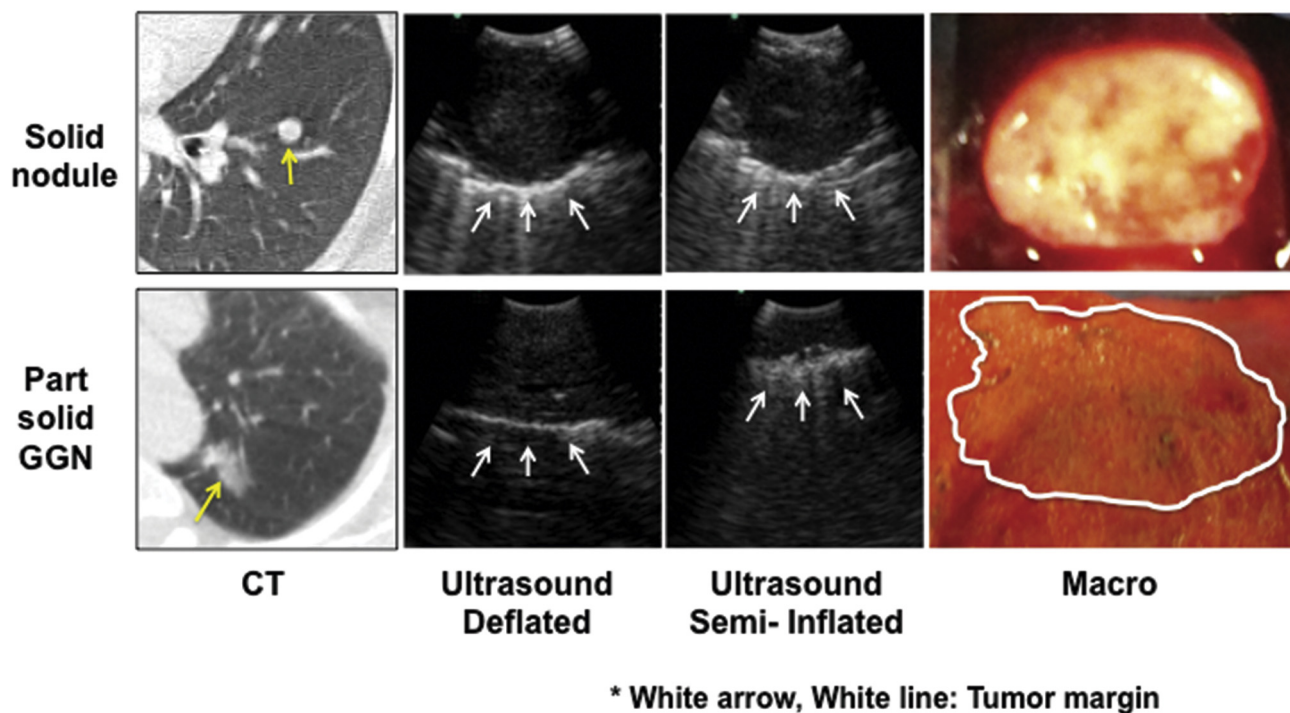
Comparison of computed tomography (CT), ultrasonography, and macroscopic (Macro) images between solid nodule and part solid ground-glass nodules (GGN) in both deflated and semiinflated states. Tumor margins are easier to visualize in the deflated state (left) compared with when the lung is semiinflated (right). On CT images, yellow arrows indicate tumor. On ultrasound images, white arrows indicate deepest border of lung tumor. On macroscopic image, white line marks entire tumor margin.
